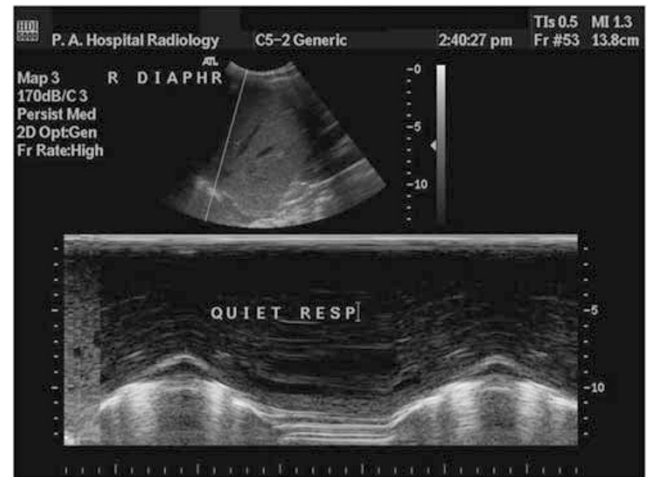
M mode ultrasound trace of normal diaphragm movement. Normal trace of diaphragmatic movement. In inspiration, movement is caudal, with the corresponding M mode trace being upwards as the diaphragm moves toward the probe. In expiration, the M mode trace is downwards as the diaphragm moves away from the probe
